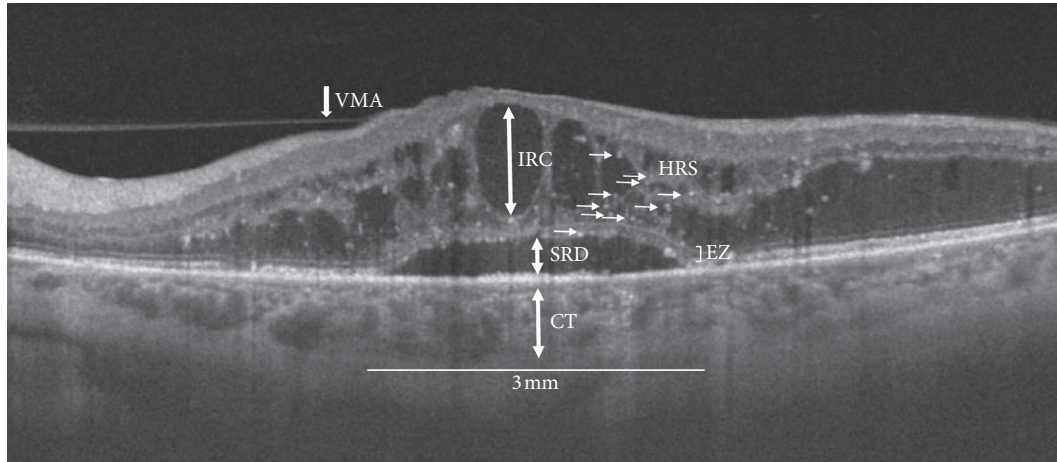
Swept-source optical coherence tomography radial scan (9 mm) of a patient with diabetic macular edema and subfoveal neuroretinal detachment showing structural biomarkers evaluated within a 3 mm area centered on the fovea: CT: choroidal thickness; SRD: serous retinal detachment; EZ: ellipsoid zone integrity; IRC: intraretinal cysts; HRS: hyper-reflective spots; VMA: vitreomacula adhesion.
